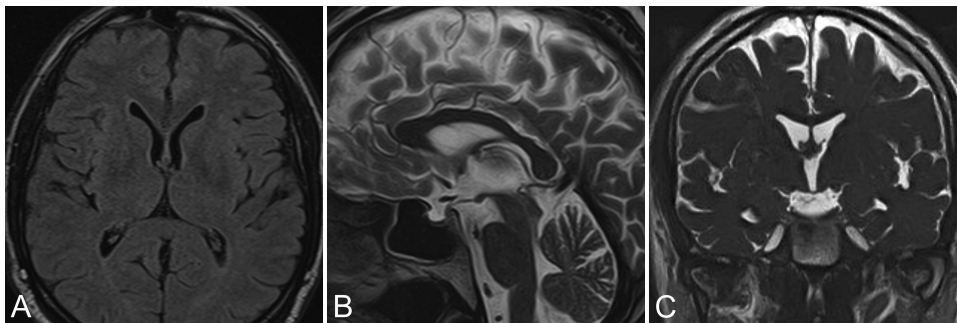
Last control MR images and the last imaging study performed to date. The same signal, presumed to be remnants of the cyst wall of the CC, can be observed in the axial (A), sagittal (B), and coronal (C) planes. The patient is scheduled for another control imaging appointment in 4 years.
